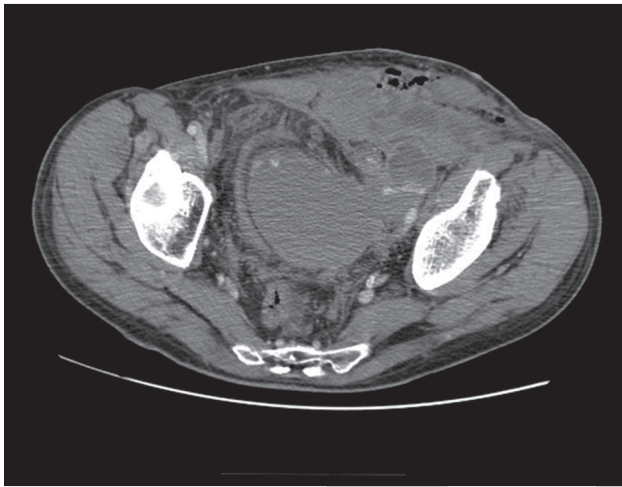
Axial MDCT scan shows incarcerated left inguinal hernia leads to small bowel obstruction. CT scan obtained at a lower level demonstrates an incarcerated small bowel segment in an inguinal hernia.
